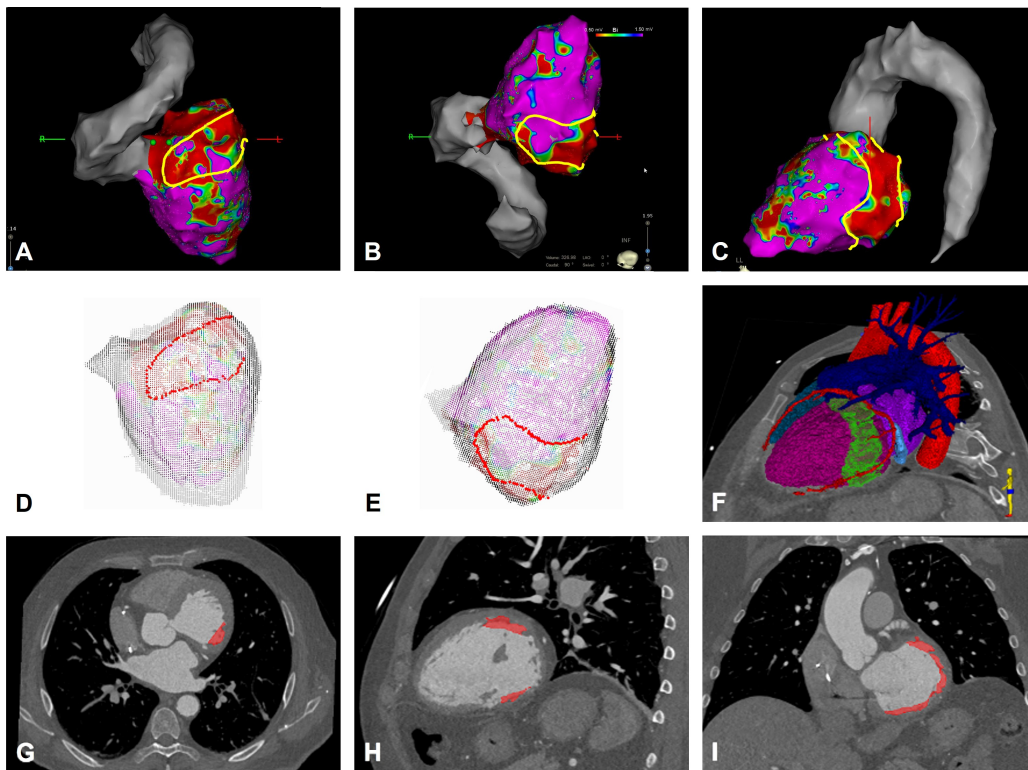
Case 4. (A-C) Electroanatomical mapping data with the marked ventricular tachycardia (VT) region (yellow) in superior (SUP), inferior (INF) and left lateral (LL) views from CARTO 3 system. (D, E) SUP and INF views during the 2D-3D registration with the defined VT target points (red). (F) A 3D rendering (LL view) of the resulting clinical target volume (CTV, green) shown in the context of the cardiac chambers and great vessels, as segmented from the cardiac computed tomography (CT). (G-I) Axial, sagittal and coronal views of the cardiac CT with the final CTV (red).
